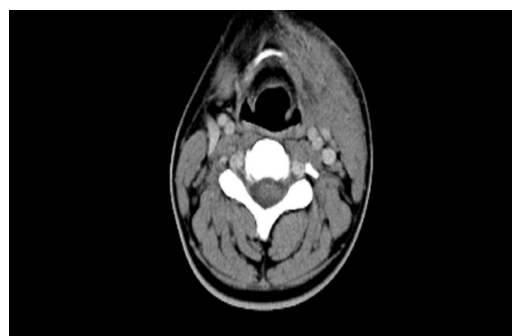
CT scan showing a solid heterogeneous mass-like lesion measuring 5 × 10 cm in the anterior aspect of the left sternocleidomastoid muscle.
